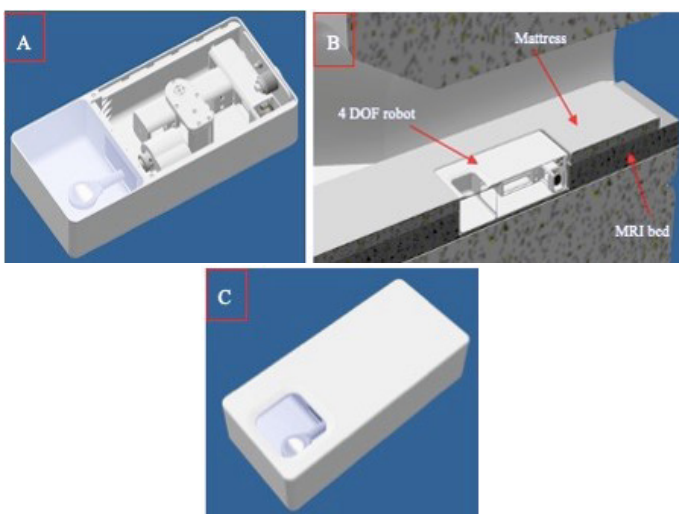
(A) Complete CAD design of the robotic system showing the interior of the device, (B) Cross section of the device in the MRI (isometric view), (C) Complete design of the robotic device including the cover.
